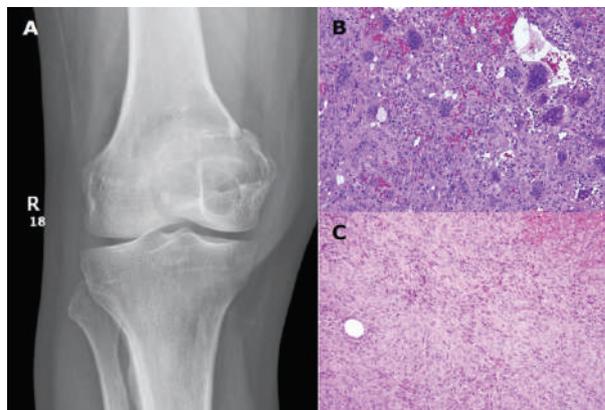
(A) X-ray with Fracture Line (B) HE Section with Hemorrhage x200 and (C) Areas Composed Entirely of Stromal Cells with Storiform Pattern x200
